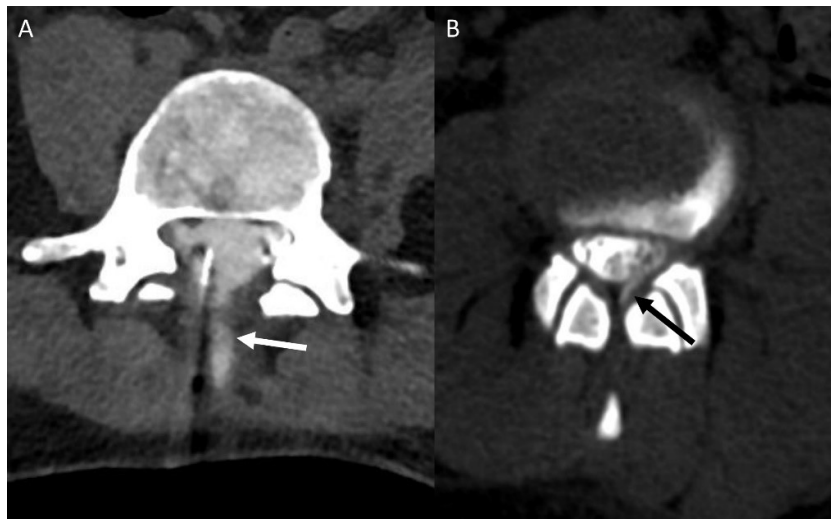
Two examples of extradural contrast after intrathecal injection that limit the ability of myelography to detect a dural defect. (A) Image from a lateral decubitus photon counting detector CT myelogram that shows contrast extending posteriorly along the needle tract (white arrow). (B) CT imaging following DSM, after the needle was removed, and shows extradural contrast at the site of prior needle placement (black arrow). Both findings would obscure the detection of contrast leakage through a dural defect present prior to myelography.
